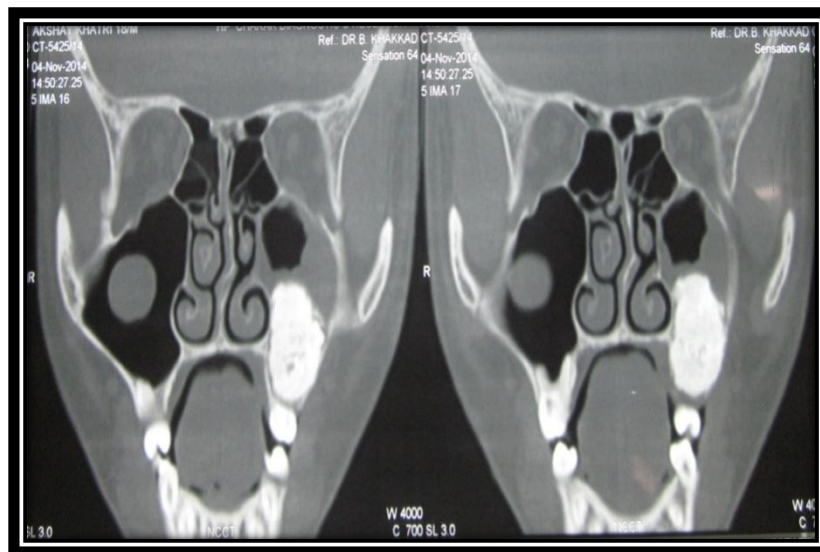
Coronal section CT showing radiopacity in left maxilla extending into maxillary sinus, and well defined radiopacity in right side maxilla attached to sinus lining.
